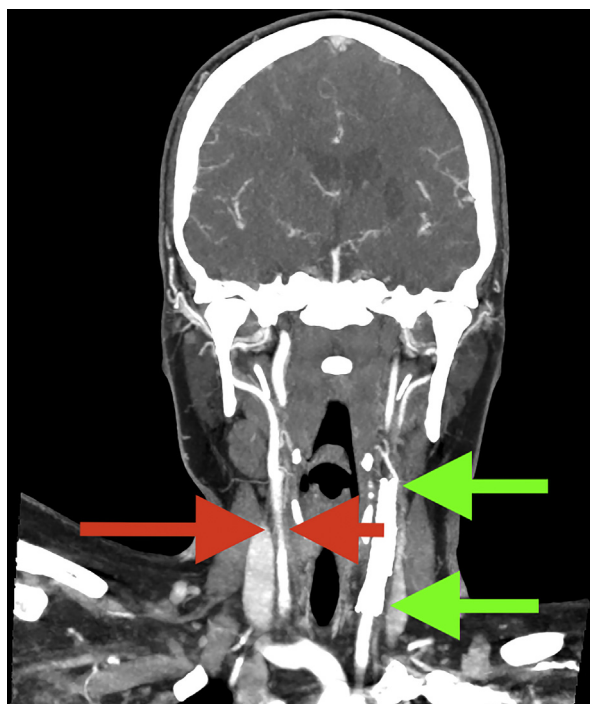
Stenosis of the right common carotid artery (red arrows) demonstrated on computed tomography angiogram, 6 months following the patient's stroke. Also shown is the left common carotid artery stent (green arrows).
